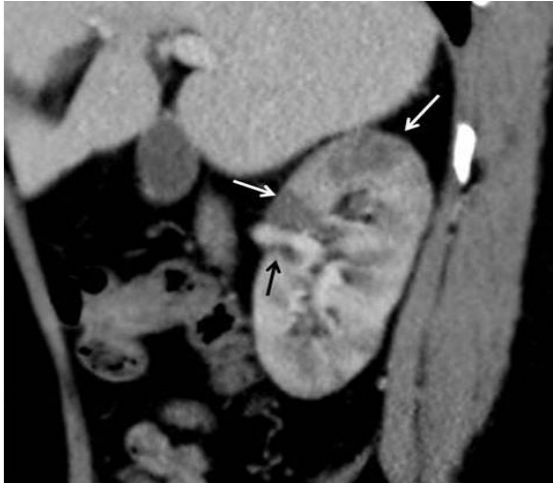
(e) MDCT images reveal partial thrombosed isolated dissection of right renal artery (white arrows). Also focal parenchymal infarctions of right upper pole kidney is noted (black arrows). Follow-up CT image performed after treatment
